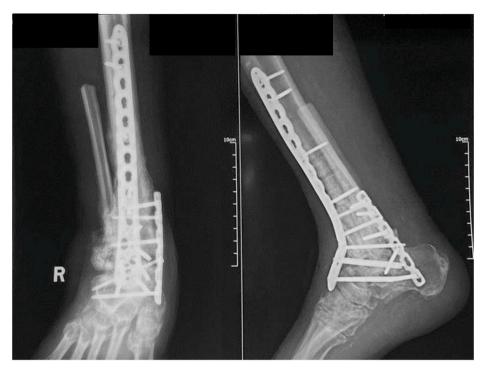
Right ankle radiograph of anteroposterior and lateral view 3 months after procedure.
